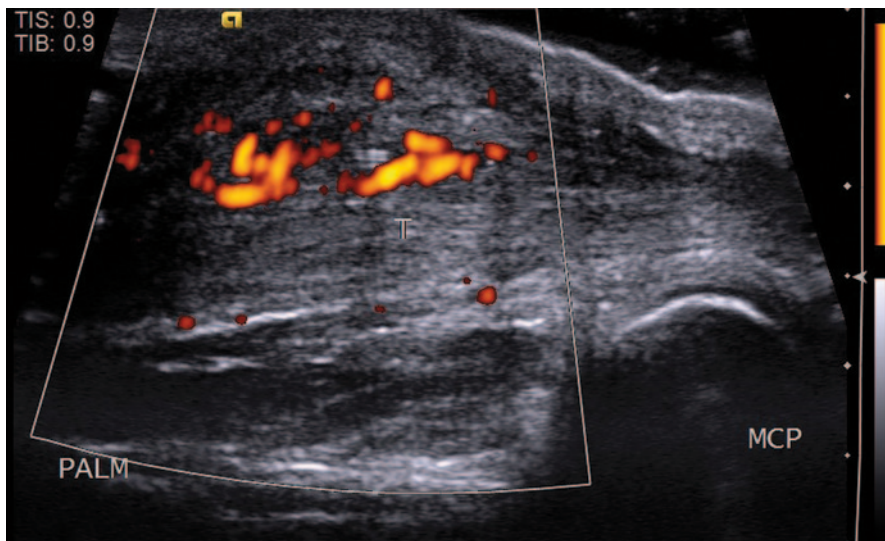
Postoperative tendon (*T*). The flexor tendon is thickened and surrounded by thick echogenic tissue that exhibits Doppler signal, representing adhesions
